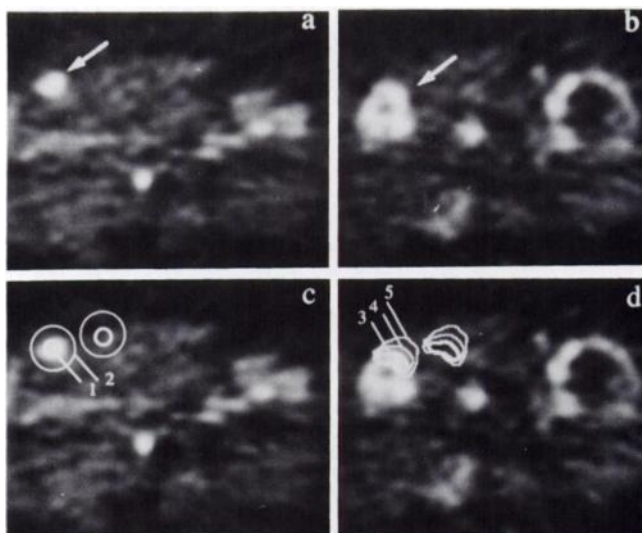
Images of liver metastases from a FDG PET melanoma study. Arrows point to (A) lesion 1 on plane 8 and (B) lesion 2 on plane 12. ROIs 1–5 on (C, D) were the tumor ROIs, the unlabeled ROIs were the corresponding reference ROIs for 6P model with same sizes and shapes. ROI size: ROI 1 (2.3 cm²), ROI 2 (16 cm²), ROI 3 (6.0 cm²), ROI 4 (7.1 cm²), and ROI 5 (10.3 cm²).
